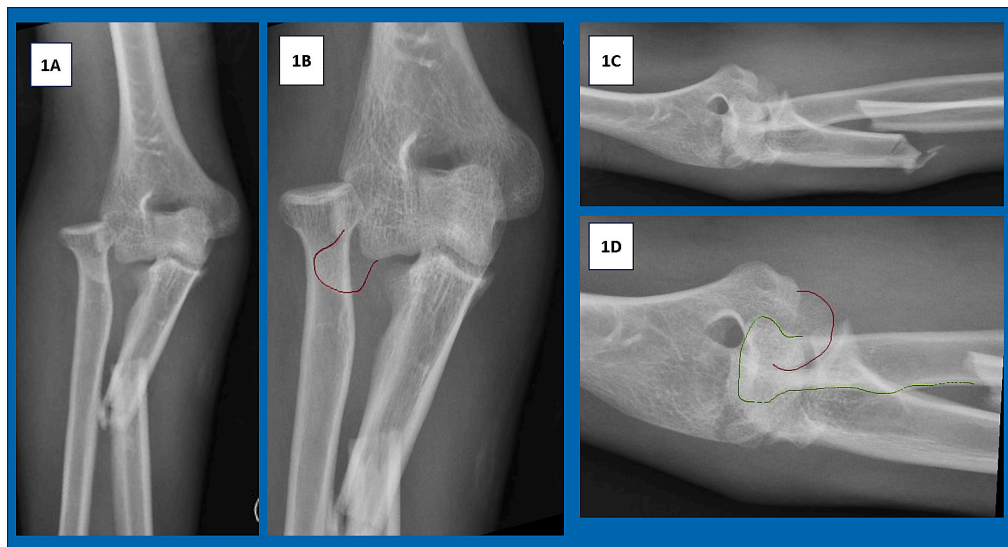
Pre-operative X-ray image showing Monteggia fracture dislocation AP view and Lateral view. A and B: In AP view there is a double shadow of capitellum fragment at the level of radial neck which has been highlighted (red outline marking). Figure C and D: In lateral view radial head appears to be posterior to capitellum which has been outlined in D with red line showing capitellum and green line showing radial head.
